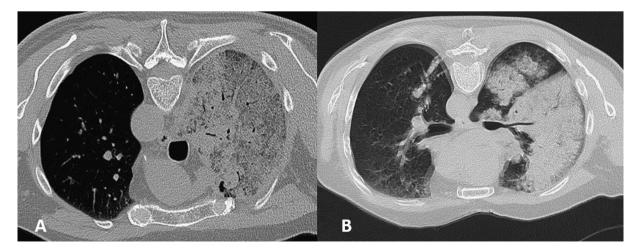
Chest CT scan. A- Chest CT scan showes mixed ground-glass and lobar consolidation involving the right superior lobe, with associated air bronchogram and thickened interlobular septa. B- Chest CT scan showes ground glass with crazy paving appearance in the inferior right lobe and consolidation of superior right lobe, with air bronchogram.
